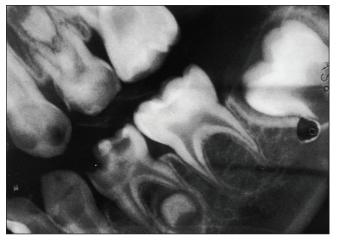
A bite-wing radiograph of the left side. Note the thin tapered roots of the mandibular primary second molar, and the small size of the mandibular and maxillary first premolars. The mandibular second premolar is not visible. Severe caries is present on the maxillary and mandibular primary teeth.
